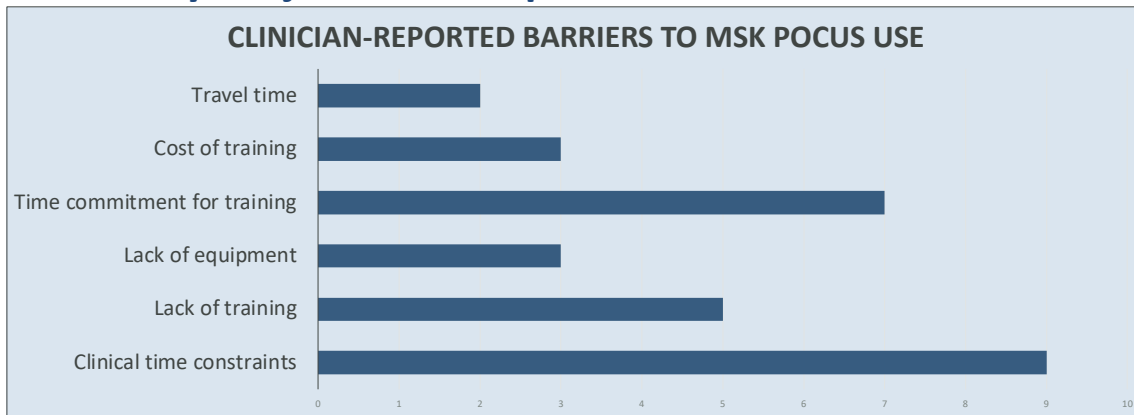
Clinician-Reported Barriers to Musculoskeletal Point-of-Care Ultrasound Use and Training.
